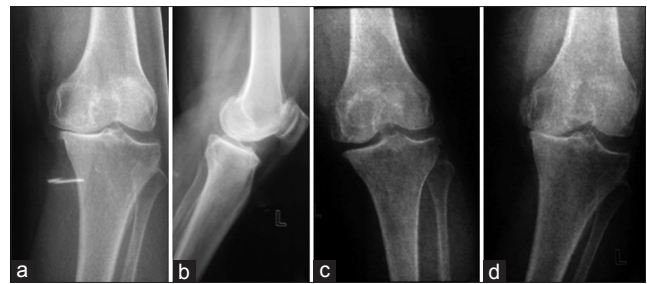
Preoperative radiographs of the patient. (a) Antero-posterior view of left knee showing complete loss of joint space in the medial compartment; however, the lateral compartment is intact. (b) Lateral view showing femoral condyles centered over the tibial plateau suggestive of intact ACL.^[6] (c) Valgus stress view showing opening of the medial joint space, correction of the varus deformity on stress and a maintained lateral compartment. (d) Varus stress view showing bone on bone obliteration of medial joint space
